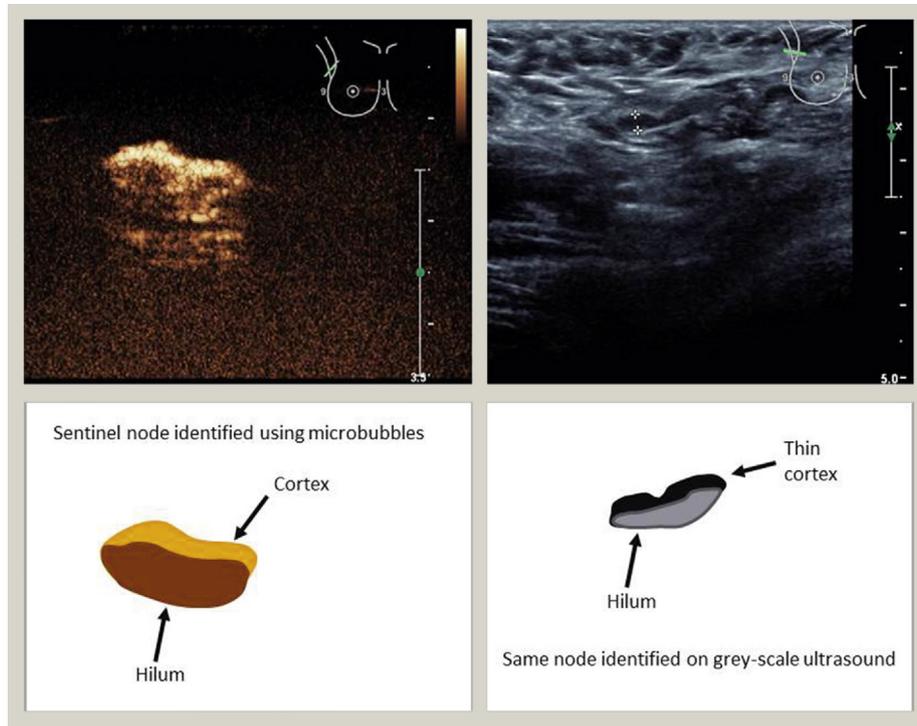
A 56-year-old woman with a screen detected 15 mm malignant mass in the right breast. Initial ultrasound of the right axilla was normal. The left ultrasound image, performed post periareolar injection of Sonovue, shows a lymph node which is lit with microbubbles indicating this to be the sentinel node. The right ultrasound image shows the same node on usual grey-scale view, there are no features on grey-scale assessment which would ordinarily have triggered a biopsy. Having identified this sentinel node due to the microbubble enhancement, a core biopsy was performed which yielded a macrometastasis.
